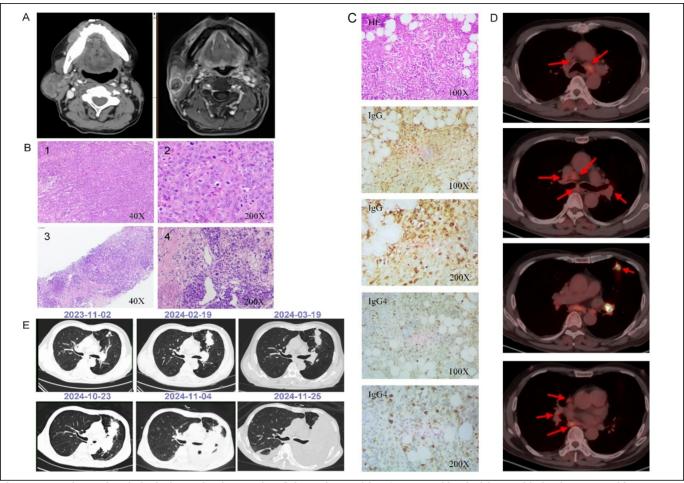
Imaging and pathological examination results of the patients with IgG4-RD combined with parotid gland cancer and lung cancer. (A) Enhanced CT (left) and MRI (right) showing nodules and enlargement of the right parotid gland. (B) The pathology of parotid salivary gland carcinoma (1-2). The pathology of lung adenocarcinoma (3-4). (C) The pathology of chronic sclerotic salivary adenitis of the right parotid gland, as well as the IHC expression of IgG and IgG4; IgG4/IgG >40%. (D) PET-CT showing the metabolism of the left pulmonary nodules and mediastinal lymph nodes. (E) The lesion of the lung mass progresses over time.
